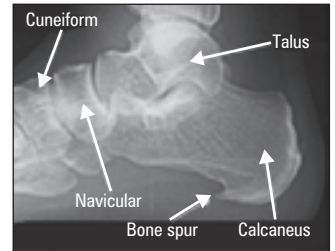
X-Ray of Bony Heel Spur
